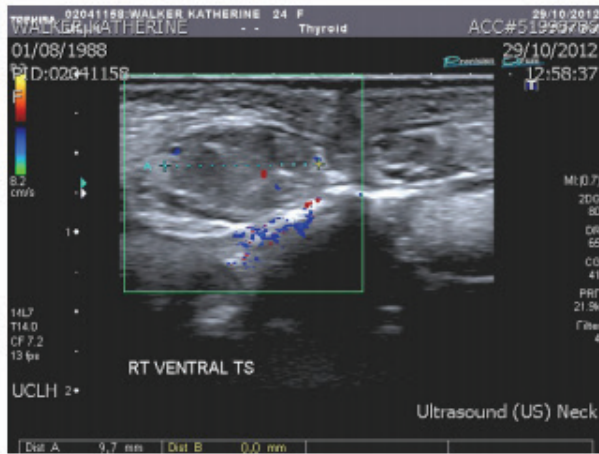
Image of Ultrasonography of the tongue measuring the dimensions of the tongue tumour
